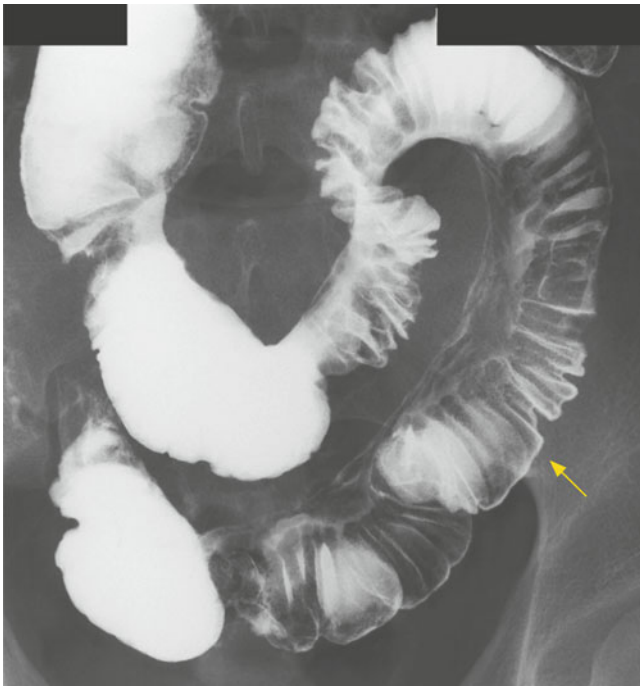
Case 7: Radiography showed multiple longitudinal ulcers causing lateral deformation of the intestine and pronounced mucosal convergence, together with irregular open ulcers on the mesenteric side. The *arrow* indicates the site of endoscopic observation
